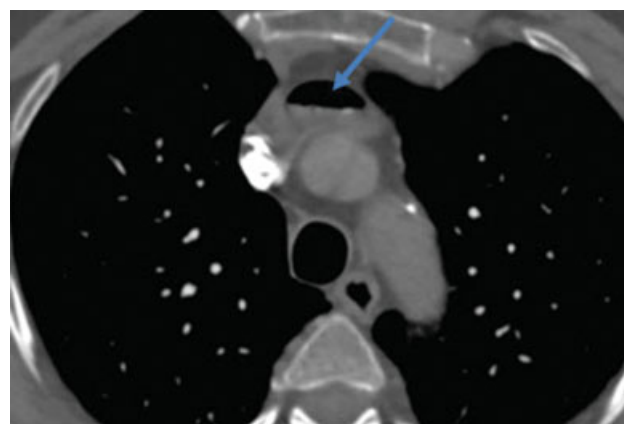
Pulmonary computed tomography angiography (CTA) axial image. Presence of air bubble in the left brachiocephalic vein of 3.4 mL (yellow arrow).
